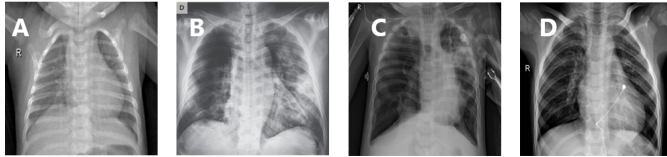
One chest X-ray image from each class of the dataset: (A) shows a normal case, (B) shows a COVID-19 case, (C) shows Viral Pneumonia case and (D) shows a bacterial pneumonia case.
